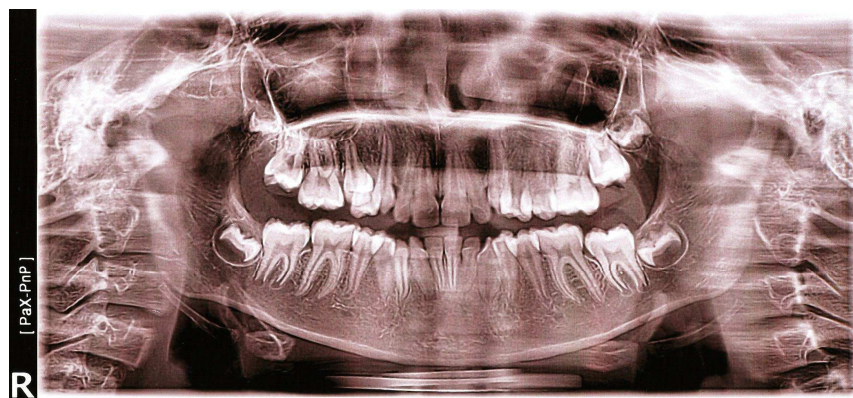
Permanent dental occlusion of a patient aged 22 years with developmental disorders 18, 28, 38, 48. There are follicular cells in which there are retinated teeth (orthopantomogram).
